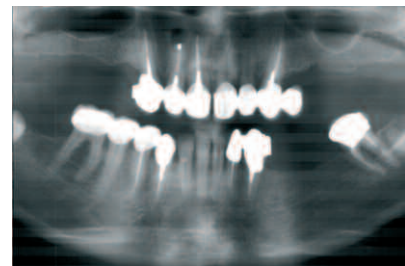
Preoperative panoramic radiograph shows a pneumatized sinus with moderate atrophic residual ridge bilaterally. A CT scan enables a three-dimensional evaluation.
